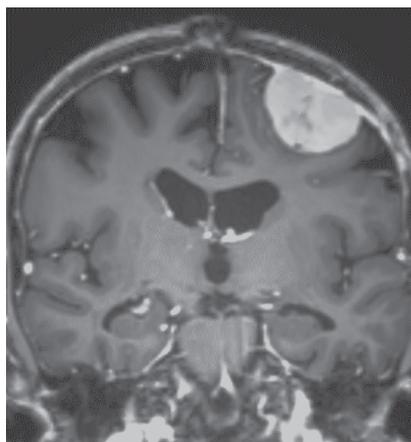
Meningioma. Magnetic resonance imaging (MRI), T1-weighted sequence with contrast of a meningioma located at left the cerebral convexity.
